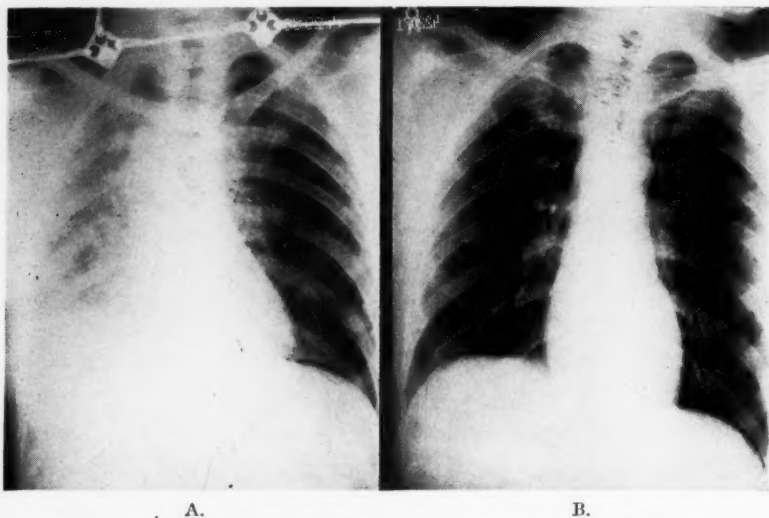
S. B., No. 422071: (A) Roentgenogram 36 hours following bilateral inguinal herniorrhaphy. Atelectasis, right lung. Bronchoscopy performed same day because of ineffectual cough and retained bronchial secretions. 25 cc. thick mucopurulent secretion aspirated from trachea and right bronchial tree. Cough remained ineffectual. Accordingly, two subsequent aspirations by tracheobronchial suction on same day. Two aspirations by same method on following day until cough became effective. Convalescence satisfactory thereafter. (B) Roentgenogram six days later reveals no pulmonary atelectasis or infiltration.
